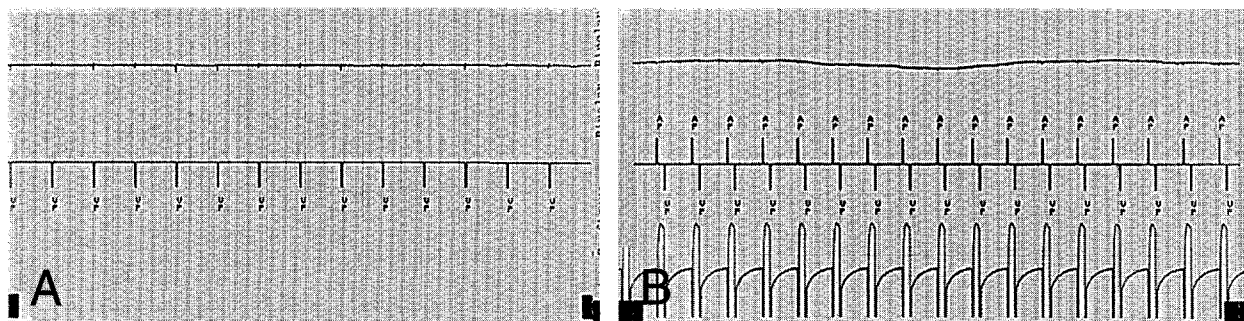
A, No interference of unipolar pacemaker activity during operation of portable radiography unit. B, No interference of bipolar pacemaker activity during operation of sonic scaler.
